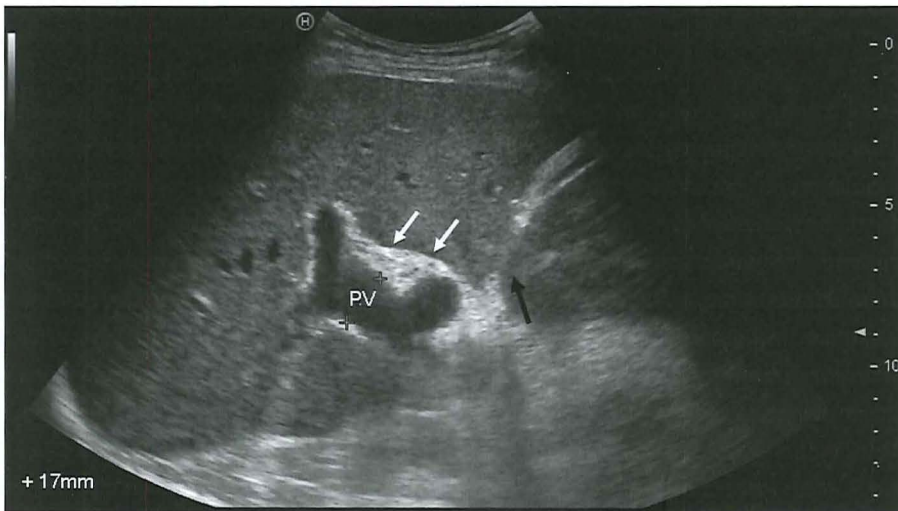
Abdominal ultrasound in a patient with INCPH demonstrating liver border nodularity (black arrow), dilatation of portal vein (PV) and thickened portal vein wall (white arrow).
